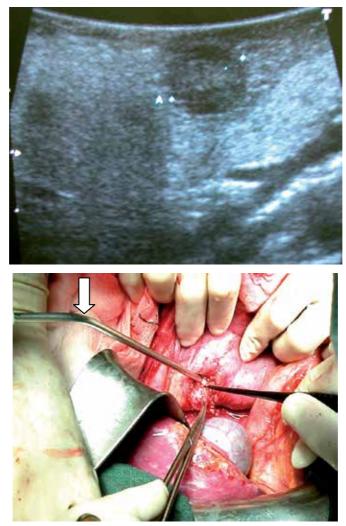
Bening insulinoma. .Upper image:. Intraoperatory ultrasonography. .Lower image:. Enucleation of the same tumoral mass.
